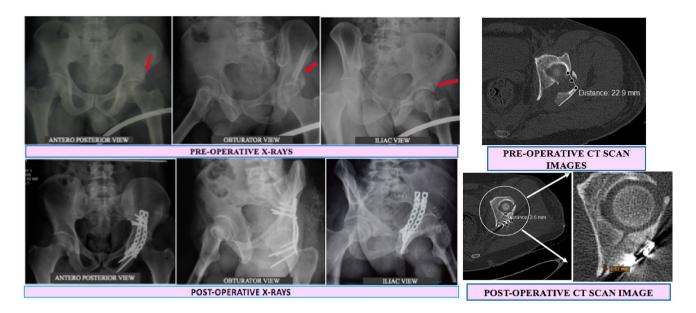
Pre-op and post-op x-ray and CT scan images
